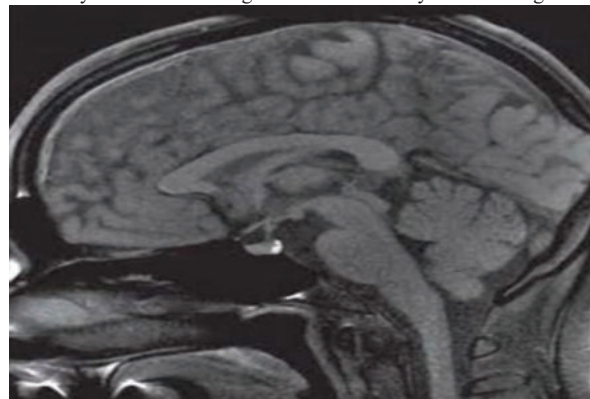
MRI image showing diminished pituitary gland.
